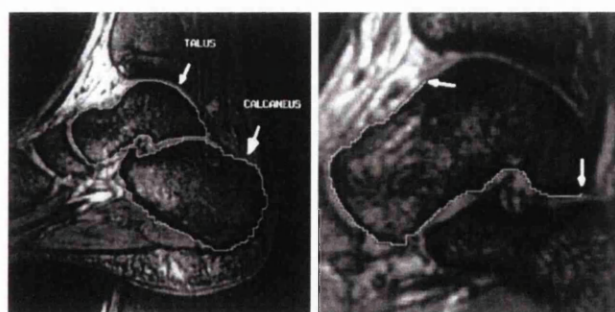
Live Lane segmentation example from [11]. The left shows an MRI slice of the foot of a subject showing the bones talus and calcaneus (marked). The Image on the right shows a zoomed-in image of a tracing on the boundary of the talus.
